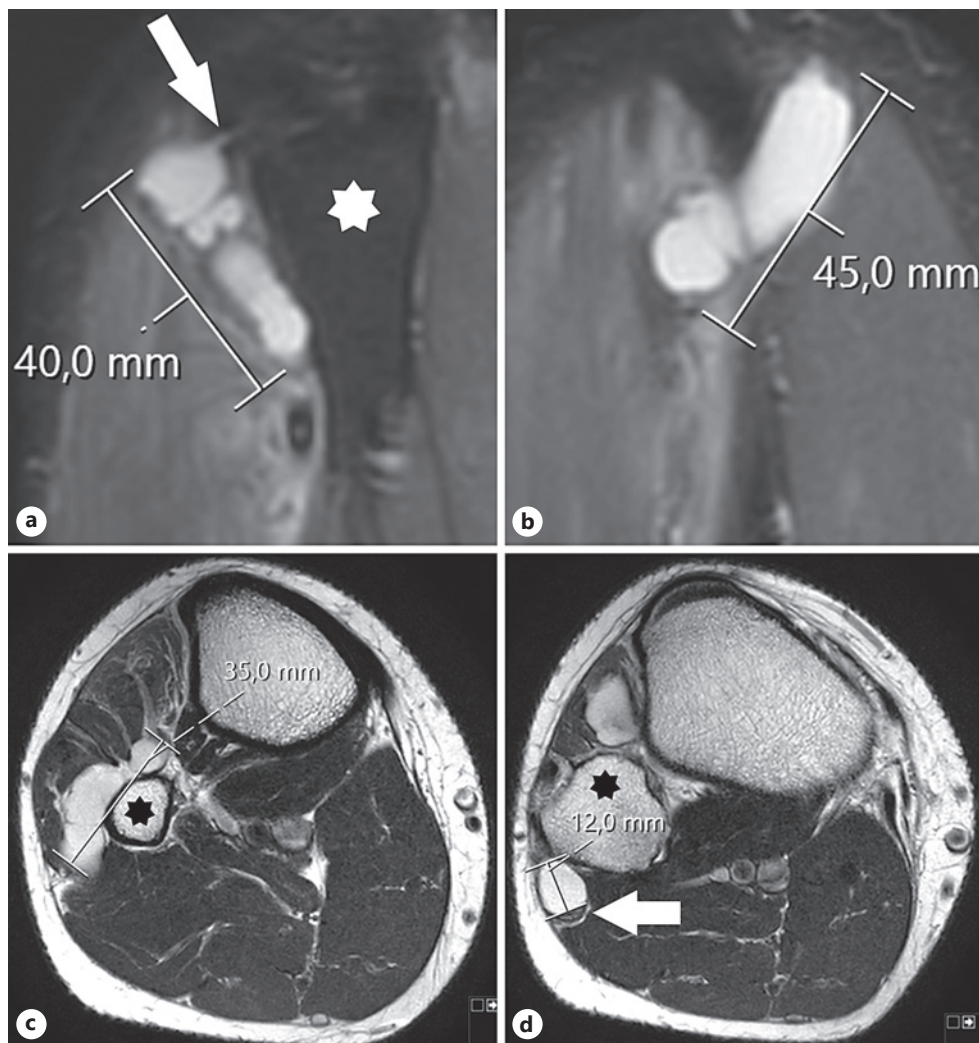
Preoperative MR images of the peroneal ganglion cyst. a Sagittal MR image shows the anterior part of the horseshoe-shaped ganglion cyst and its connection to the proximal tibiofibular joint (white arrow). The fibula is marked with a star. b Sagittal MR image shows the posterior part of the cyst that is located inside the peroneal nerve. c Axial MR image shows the transverse distal part of the ganglion cyst. The cyst is in the common peroneal nerve and the transverse limb of the articular trunk. The fibula is marked with a star. d Axial MR image shows the 12-mm transverse diameter of the posterior part of the ganglion cyst and the dorsally compressed nerve fascicles (arrow). The cyst appears to involve also the deep peroneal nerve and the nerve branch leading to TA muscle. The fibula is marked with a star.
